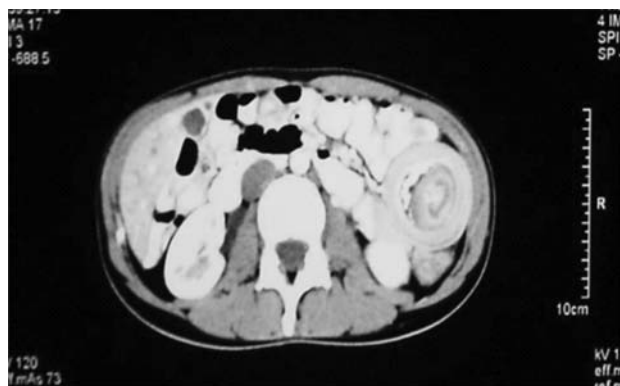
Multislice computed tomography of abdomen. Ileal intussusception in left abdomen caused by large polyp.
